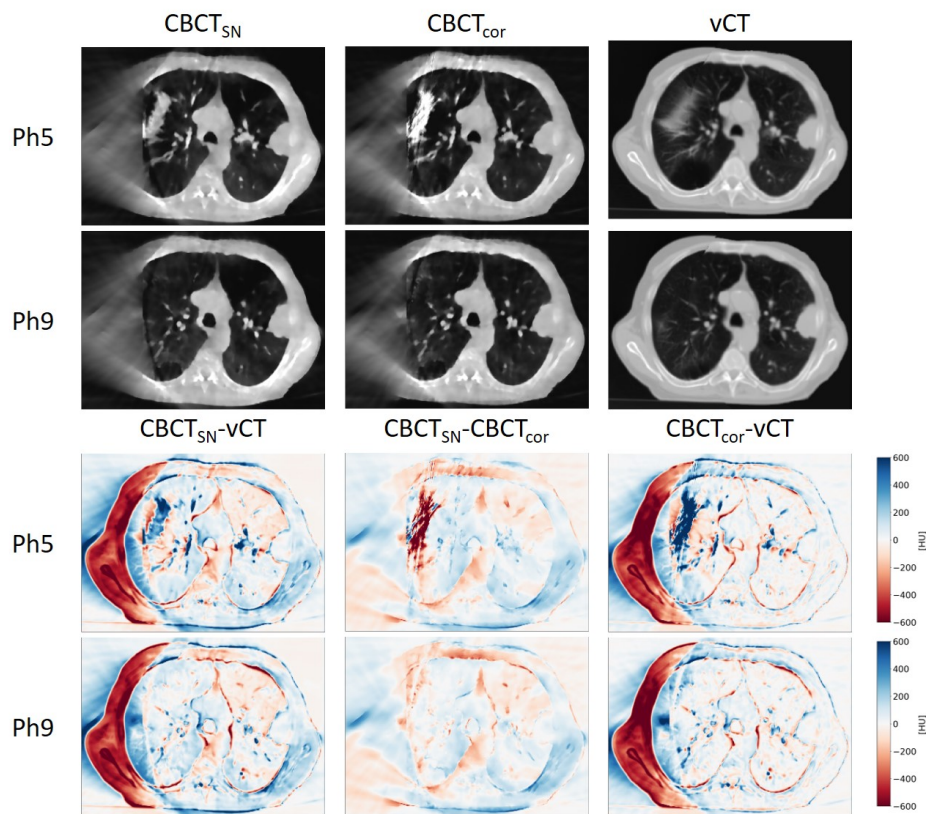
The top two rows show the extremal phases of the 4D images $4DCBCT_{SN}$, $4DCBCT_{cor}$, and $4DvCT$ displayed with level = -300 and window = 1600, for patient 25. The bottom two rows show difference images of $4DCBCT_{SN}-4DvCT$, $4DCBCT_{SN}-4DCBCT_{cor}$, and $4DCBCT_{cor}-4DvCT$ from the same patient. All images are shown in axial view.
